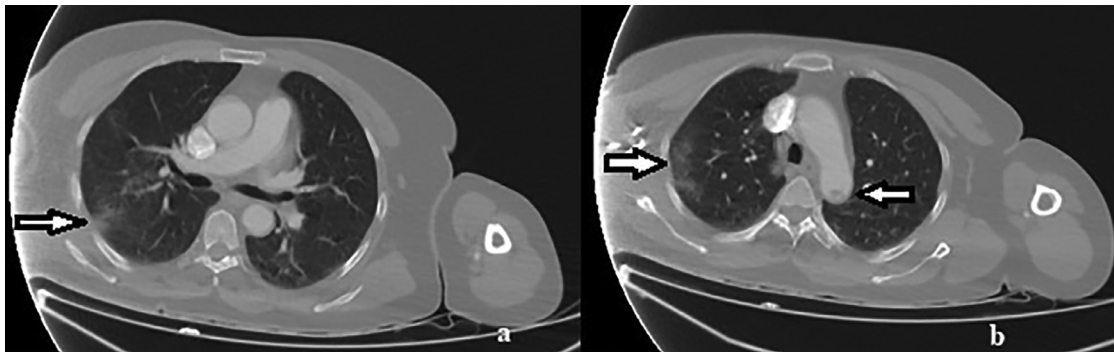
(A) Computed tomography, axial image, right arrow: the ground glass opacities in lungs. (B) Computed tomography angiography, axial image, right arrow: the ground glass opacities in lungs; left arrow: floating thrombus in aorta.
